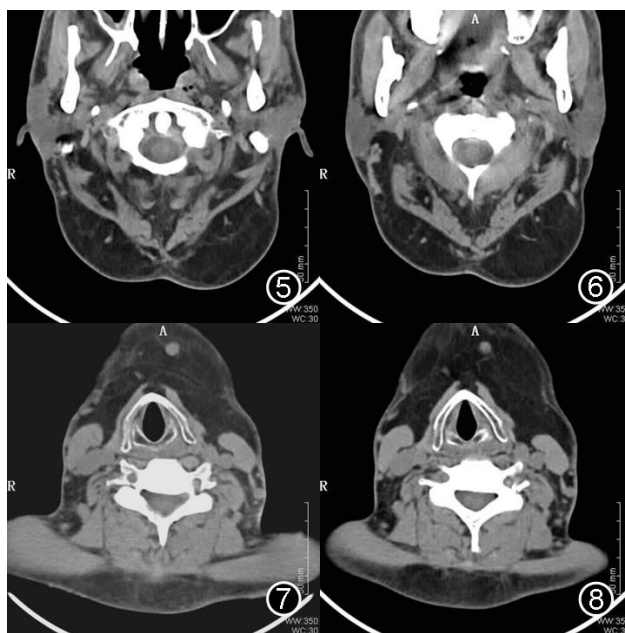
Computed tomography (CT) of the neck
